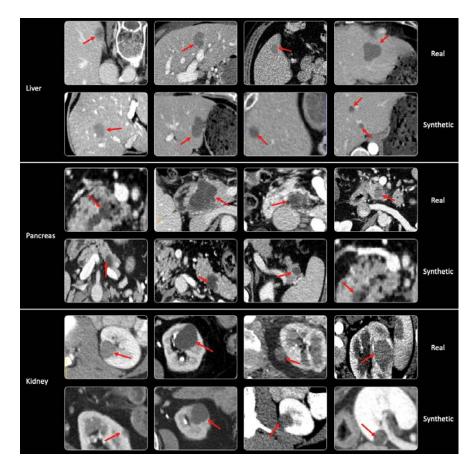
Examples of Visual Turning Test. Tubular results are presented in Table 1. Our Pixel2Cancer can be used to augment available healthy CT volumes.
